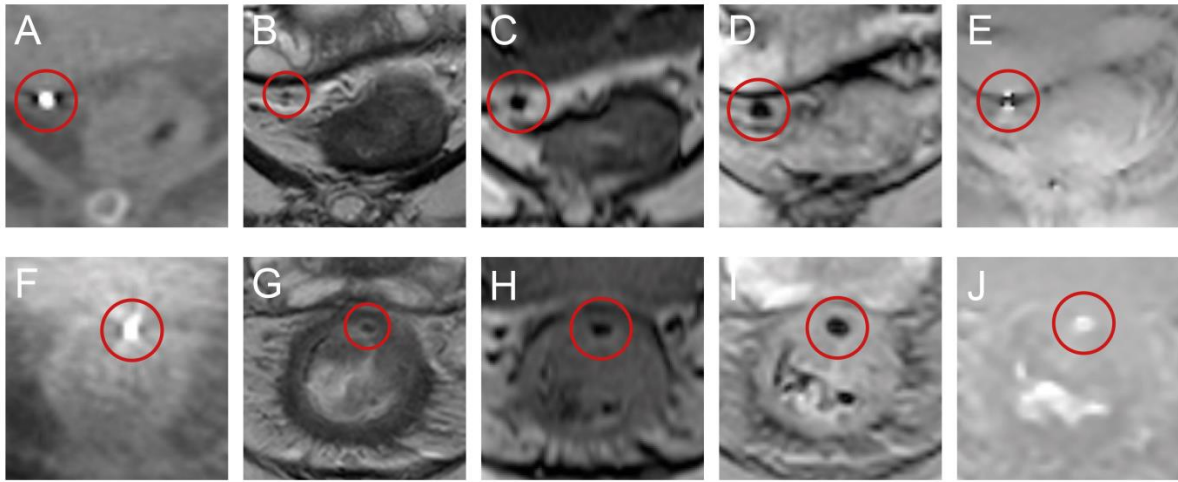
Examples of consistently identified Gold Anchor markers in two patients. One in the mesorectal fat (A-E) and one in the rectal wall at the site of the tumor (F-J) on CBCT (A+F), T2-TSE (B+G), T1 3D (short TE) (C+H), T1 3D (long TE) (D+I) and B0 (E+J).
